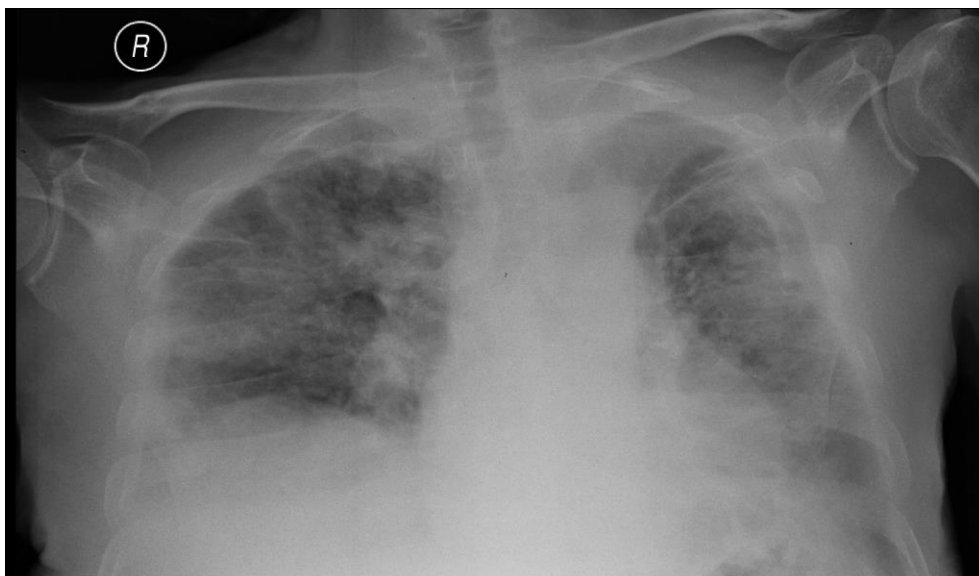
Chest radiograph showing comparative recession of opacities
